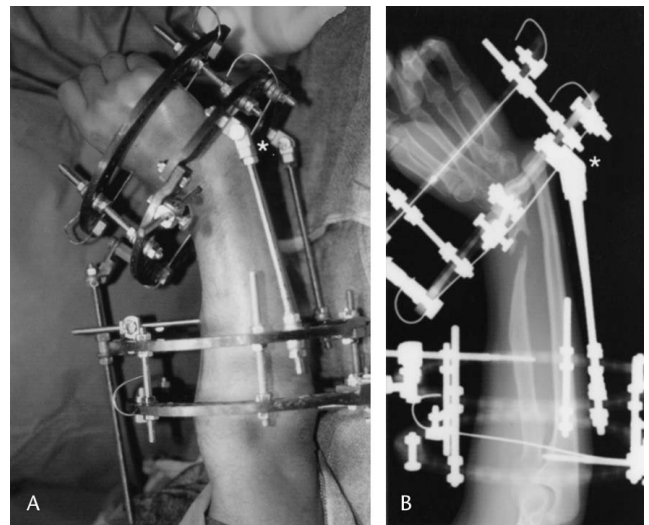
A 23-year-old man (Case 1) presented with an acquired radial club hand deformity 3 years after an open distal radius fracture that resulted in severe bone loss and deformity. (A) The intraoperative clinical photograph and (B) radiograph show the application of an Ilizarov external fixator with hinges (*) between the proximal and distal ring constructs.
